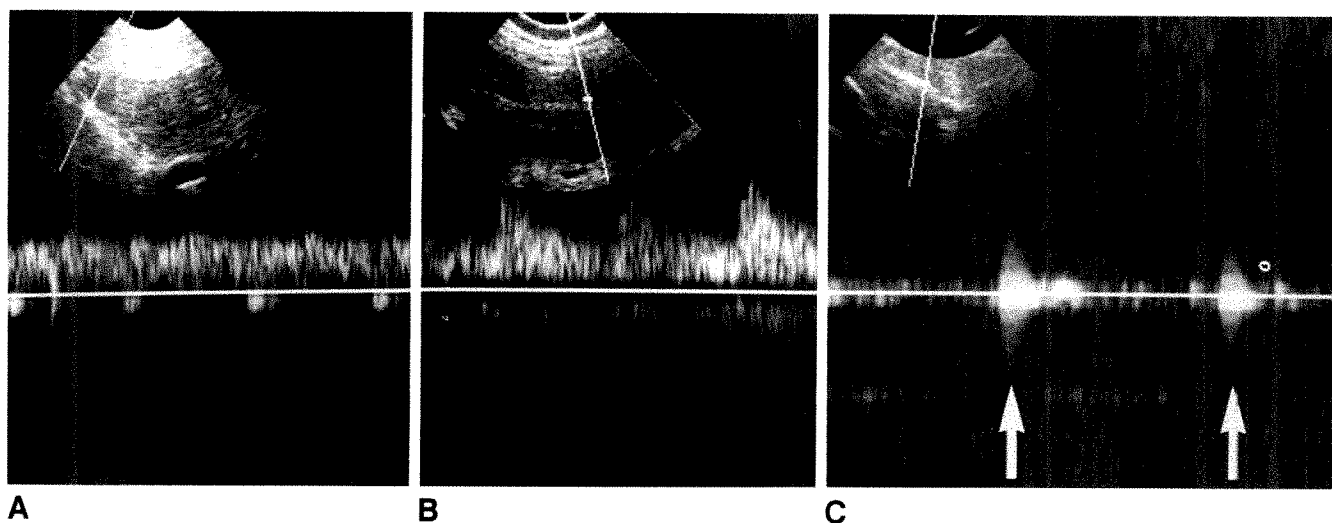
Doppler signals obtained from apparent ligamentum teres vessels included (A) venous (approximately uniform, low-amplitude hepatofugal flow), (B) arterial (with obvious systolic and diastolic components), (C) thump (transmitted cardiac or aortic pulsation—indicated by arrows) and noise (low-amplitude bidirectional signal between arrows).
